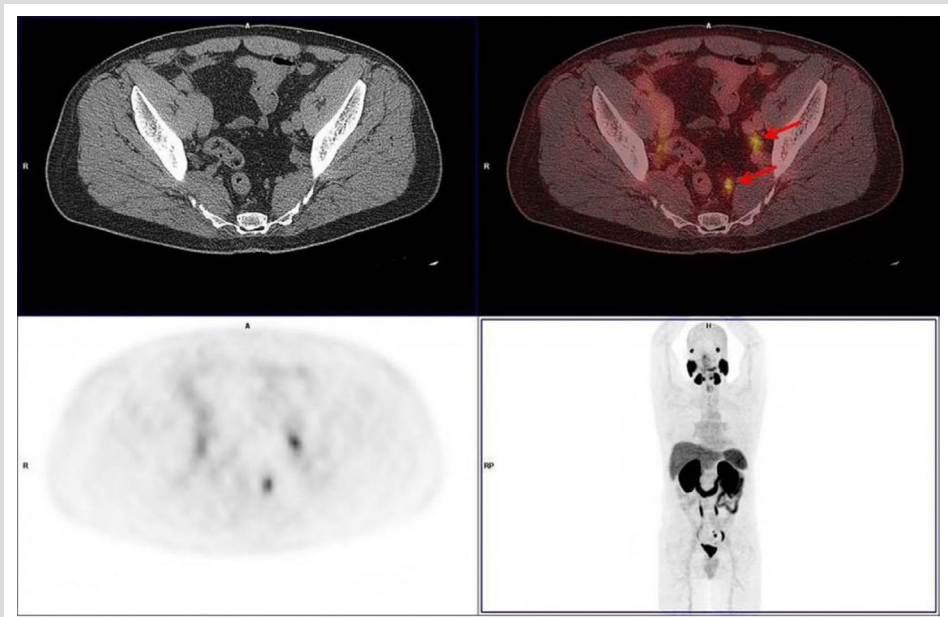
CT scans did not reveal any morphological abnormalities of pelvic lymph nodes which were, due to their high PSMA avidity, identified as suspicious only after the PET scan.
